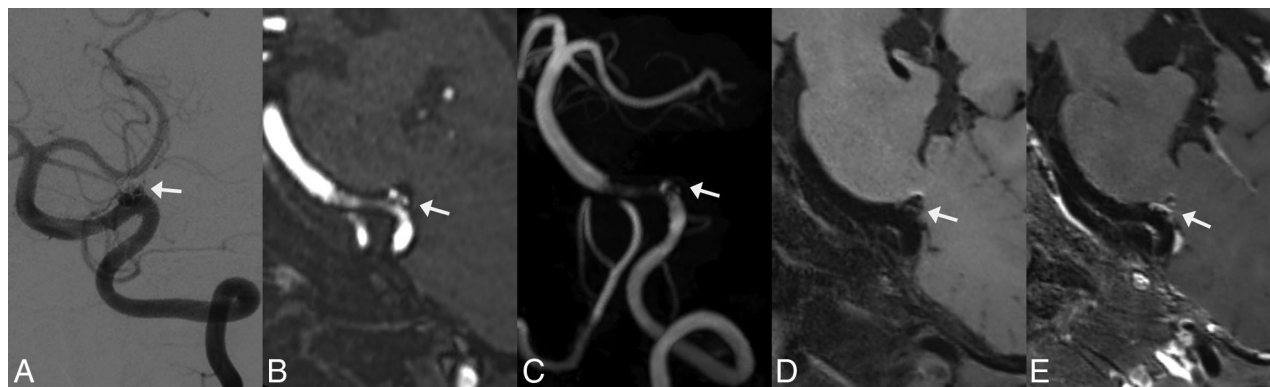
Follow-up images of a left vertebral artery dissecting aneurysm treated by LVIS stent-assisted coiling 6 months after the procedure. *White arrows indicate the location of the aneurysm.* A, DSA shows that the aneurysm involves incomplete occlusion and the stented artery is normal. B and C, MPR and MIP images of TOF-MRA show an aneurysm remnant. Moderate artifacts and a stenosis are observed at the stented artery on TOF-MRA. D and E, On pre- and postcontrast 3D T1-weighted SPACE, though no aneurysm remnant is observed, the stented artery is depicted well and indicates an absence of stenosis. The postcontrast image shows enhancement of the aneurysm wall, aneurysm lumen, and stented artery. The image quality score assigned by the 2 reviewers for TOF-MRA and 3D TIWI SPACE is 3/3 and 5/5, respectively.
